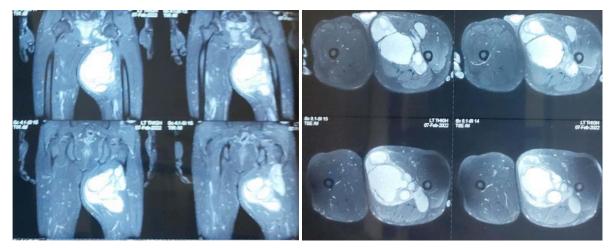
MRI showing inter- & intra-muscular hydatid cyst with multiple daughter cysts in the left thigh (a) Coronal section (b) Axial section.
